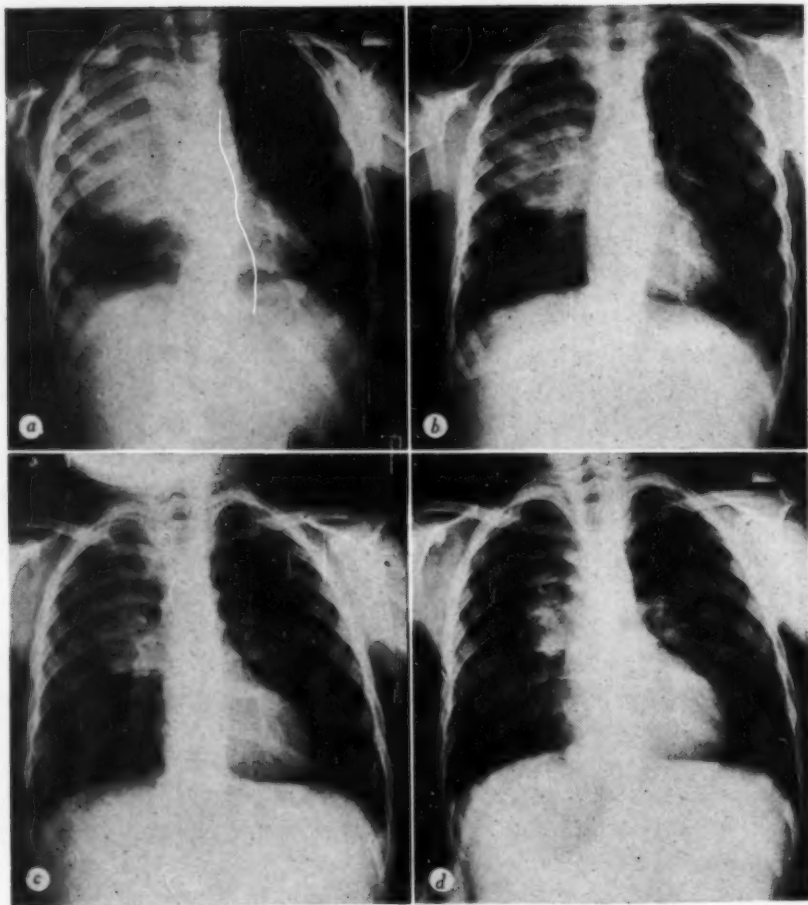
Roentgenograms of the chest in case 1.
